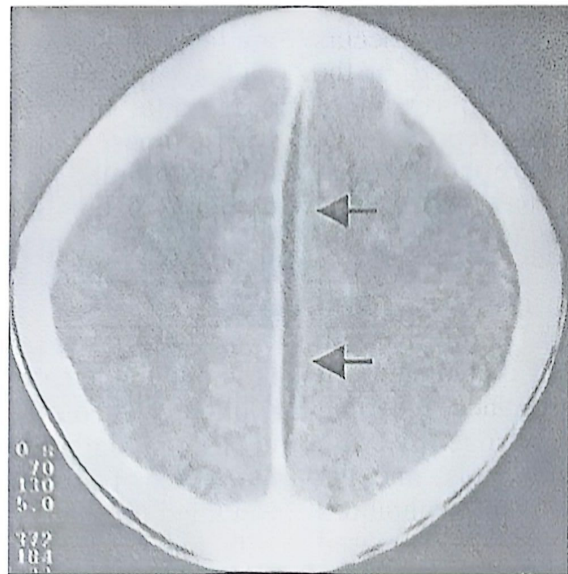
Contrast enhanced cranial Computed Tomographic scan showing parafalx collection to the left of the midline. Note marginal enhancement of the inner margin of the subdural empyema (arrows).
